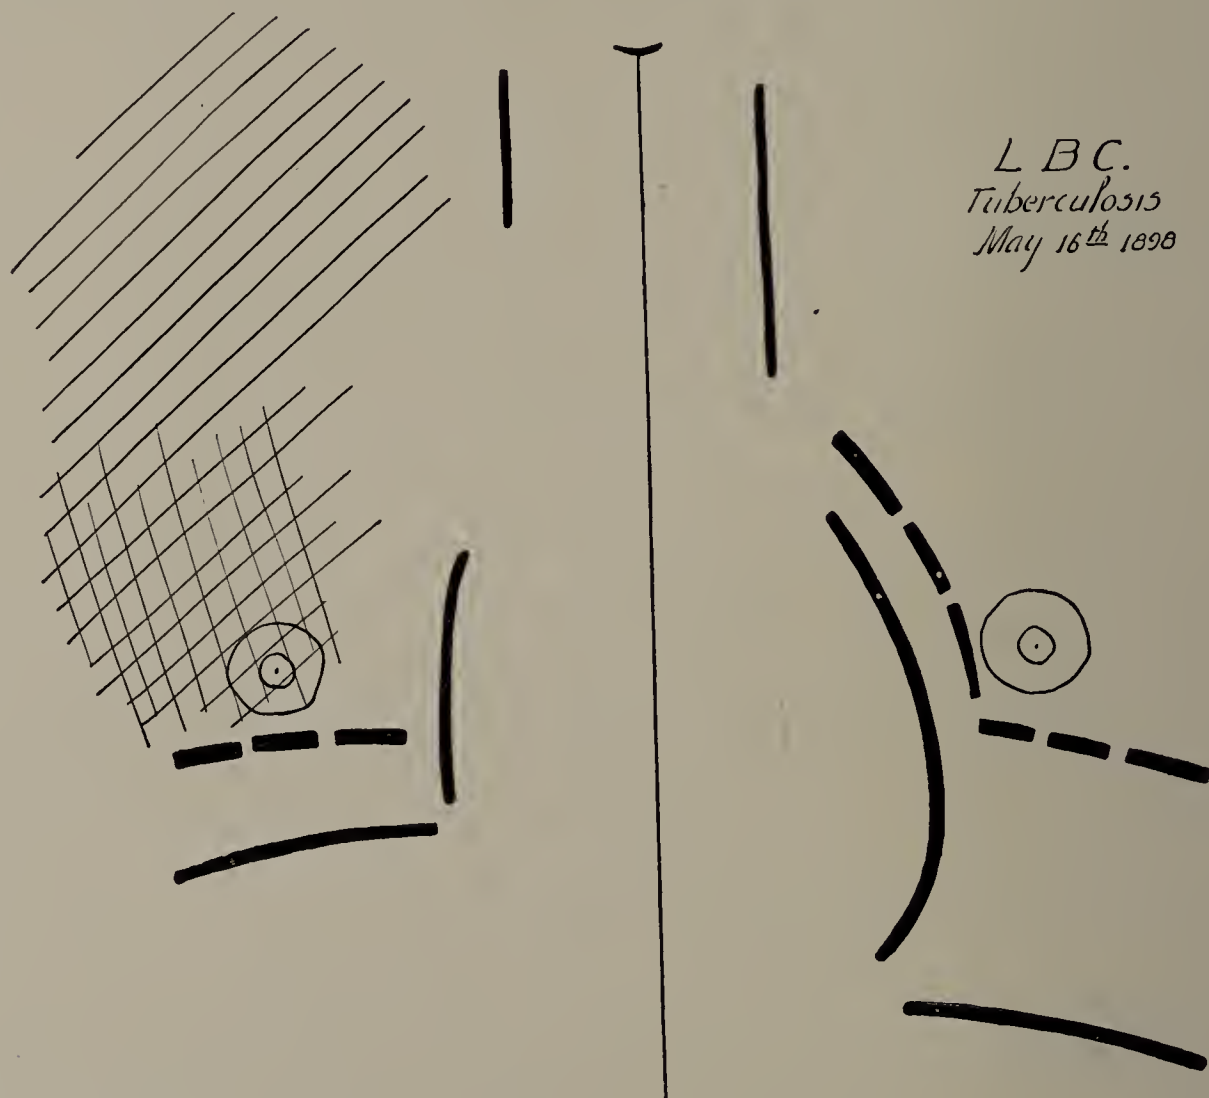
L. B. C. May 16, 1898. X-ray tracing. Right side dark throughout; excursion of diaphragm limited on this side to $2\frac{1}{2}$ centimetres. (One-third life size.)
